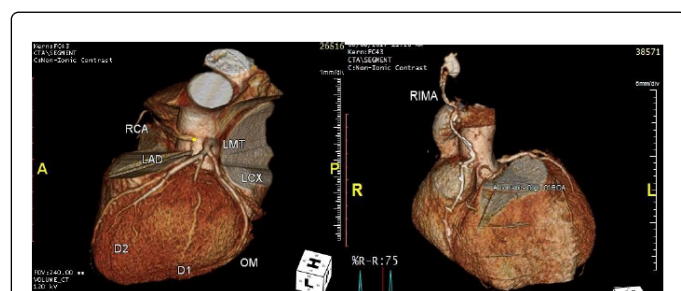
Multi-slice CT of patient two before surgery-to the left-and after surgery-to the right-with the RITA graft.
